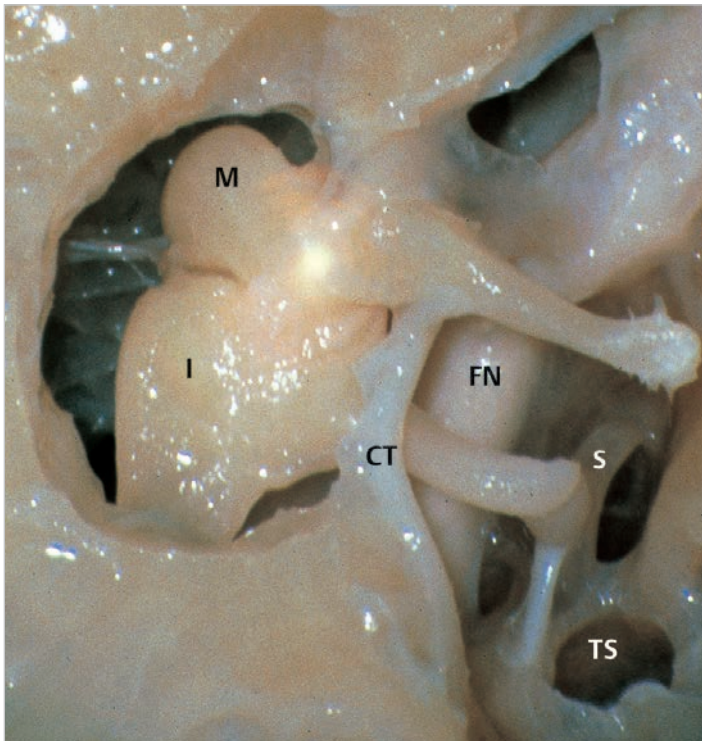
The structures seen after small atticotomy are shown. CT, chorda tympani; FN, facial nerve; I, incus; M, malleus; S, stapes; TS, tympanic sinus.
